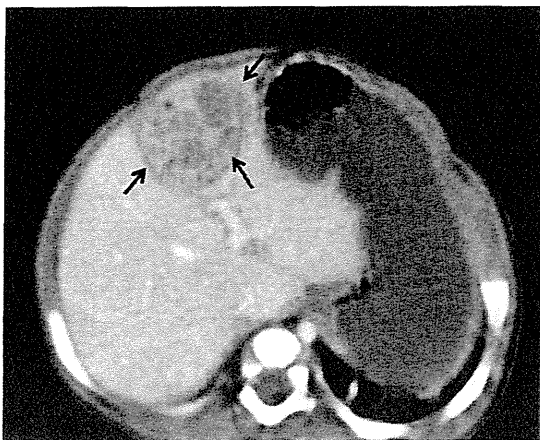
腹部造影 CT：肝 S3, S4 にかけて、造影効果をとともう内部不均一な 29.3 × 27.7 mm の腫瘍 (矢印) を認める。
